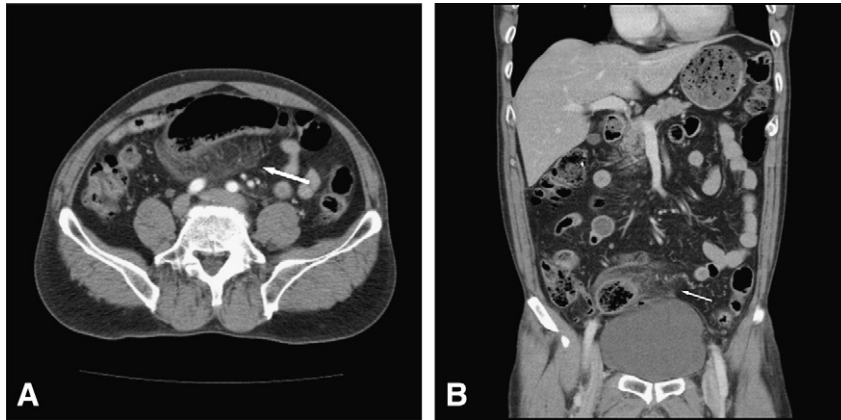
Computed tomography scan showing a loculated hematoma with mesenteric air bubbles in the rectosigmoid colon (white arrow). (A) Axial image. (B) Coronal image.
